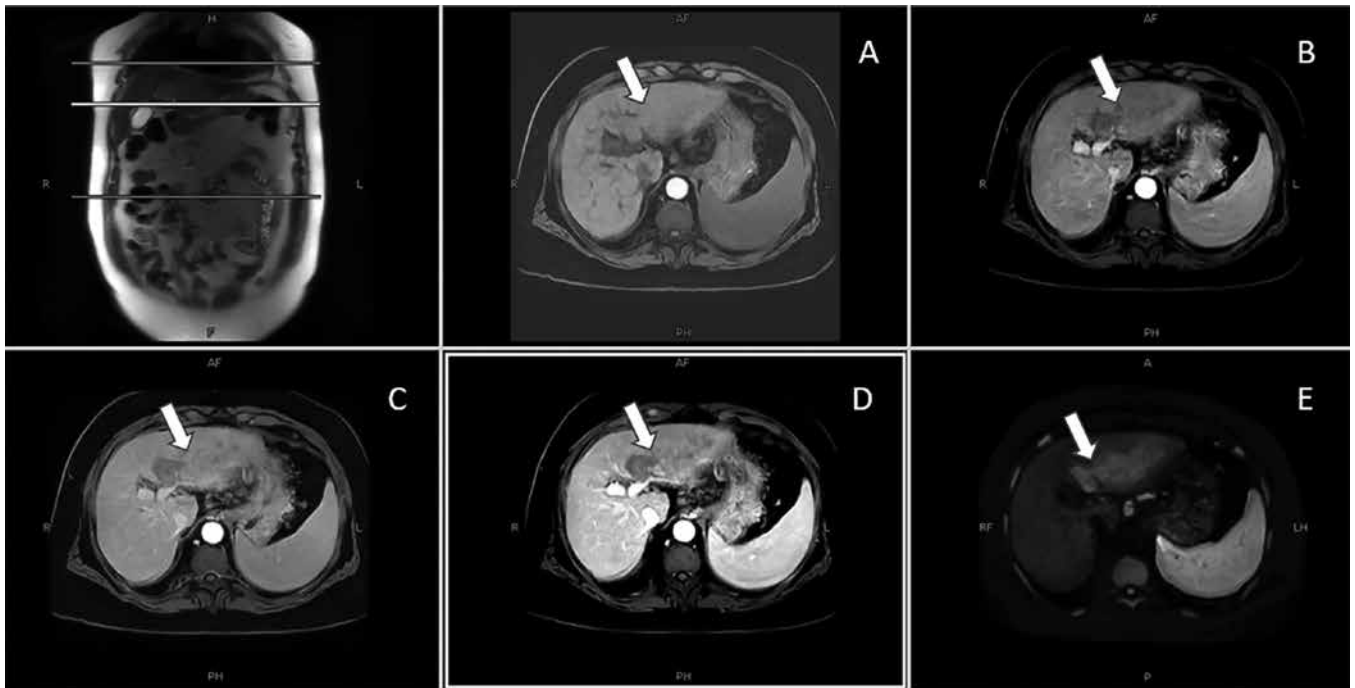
MRI Liver with Liver Specific Contrast Showing Atypical Hepatocellular Carcinoma
